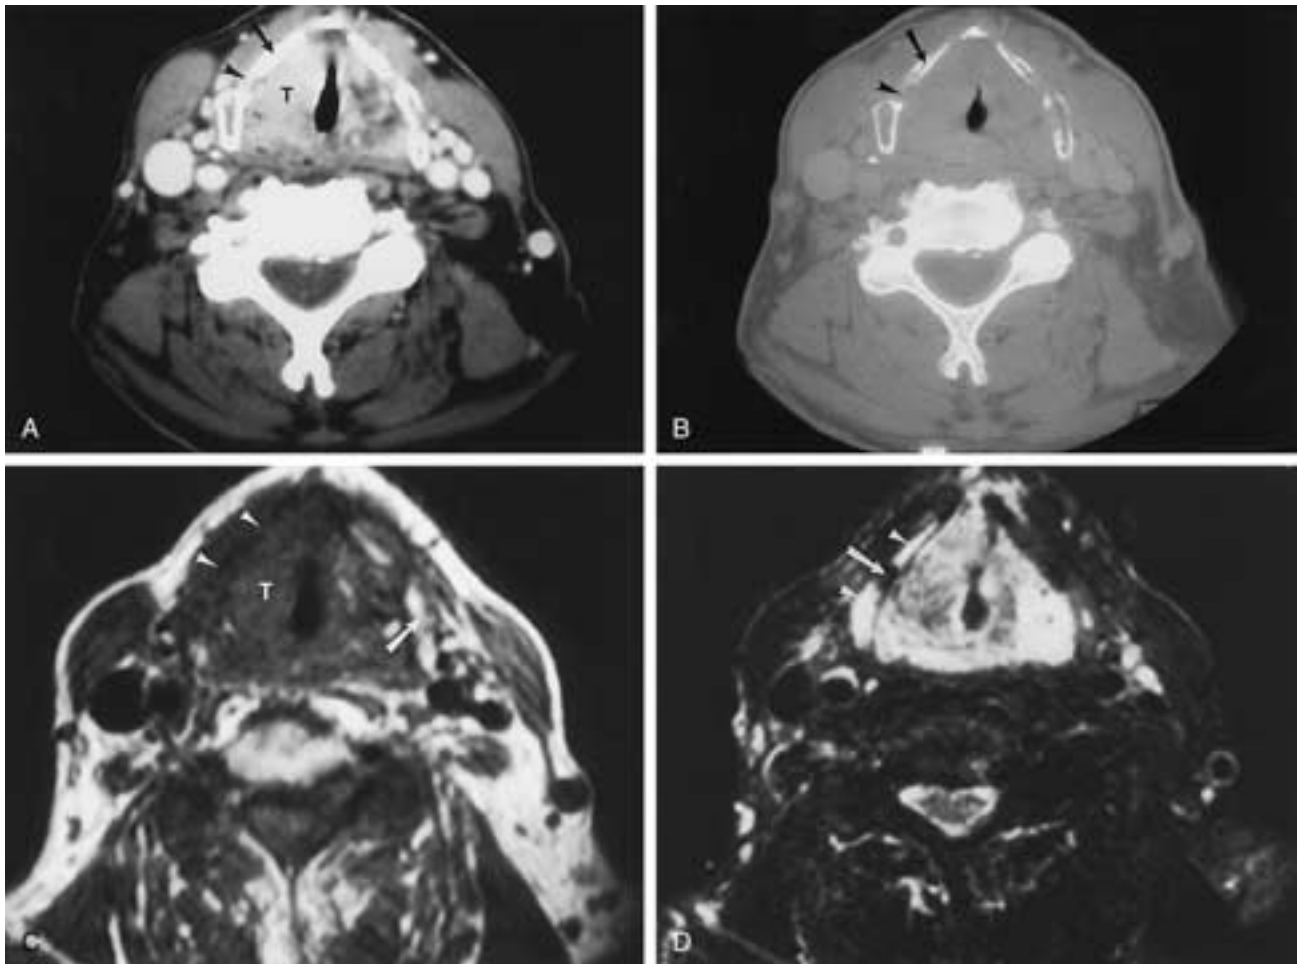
Carcinoma of the larynx invading the thyroid cartilage. A, Axial CT of the larynx shows a tumor (*T*). On the soft-tissue window the cartilage is unremarkable. Note the nonossified cartilage (*arrowhead*) and the ossified cartilage (*arrow*). B, Bone algorithm shows no definite abnormality. Again, both nonossified (*arrowhead*) and ossified (*arrow*) cartilage can be identified. C, MR T1-weighted image shows tumor (*T*). The thyroid cartilage (*arrowheads*) on the side of the tumor has intermediate signal, suggesting tumor involvement. On the opposite side there is fat in the medullary cavity of the cartilage (*arrow*). D, Axial T2-weighted image with fat suppression shows a definite increase in signal (*arrowheads*) in the involved thyroid cartilage. Note that there is relative sparing of the nonossified portion (*arrow*) of the cartilage.
